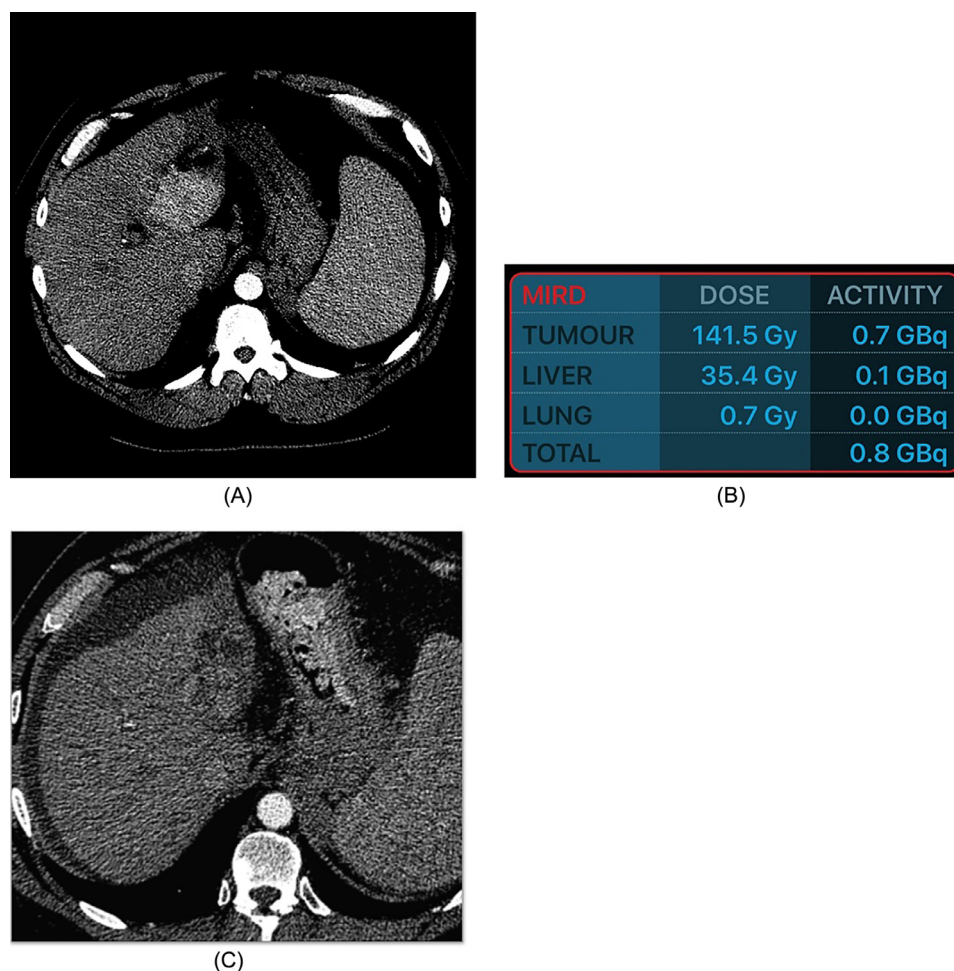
Conventional therapy using MIRD and Partition Model. 43 year old female patient with hepatitis C, radiographic evidence of portal hypertension, and a 6 cm tumor located in segment IV (A). Utilizing MIRD model and glass microspheres, the total volume of treated area (including tumor and liver) was 325cc and targeted to receive 120 Gy, assuming uniform distribution with resultant calculated activity of 0.8 Gbq (B). Three-month postadministration scan demonstrates downstage of tumor to within Milan criteria and subsequent transplant (C). If utilizing the partition model, 0.8 Gbq would have resulted in a tumor target dose of 141.5 Gy (dosimetry screen shot published with permission from the DAVYR app).
